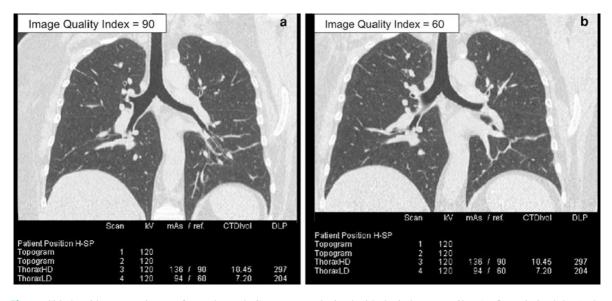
Side-by-side comparisons of unenhanced CT scans obtained in a 60-year-old obese woman with stage IV breast cancer and a BMI at 32 kg/m^2 . As in Fig. 8, the only modified parameter is the image quality index of the tube current modulation system. The first acquisition is performed with an index at 90 mAs (a, standard dose) whereas the second is
